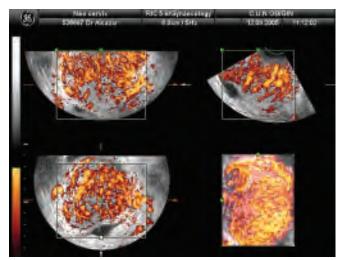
Three-dimensional power Doppler appearance of cervical vascularity in a case of uterine cervical cancer
